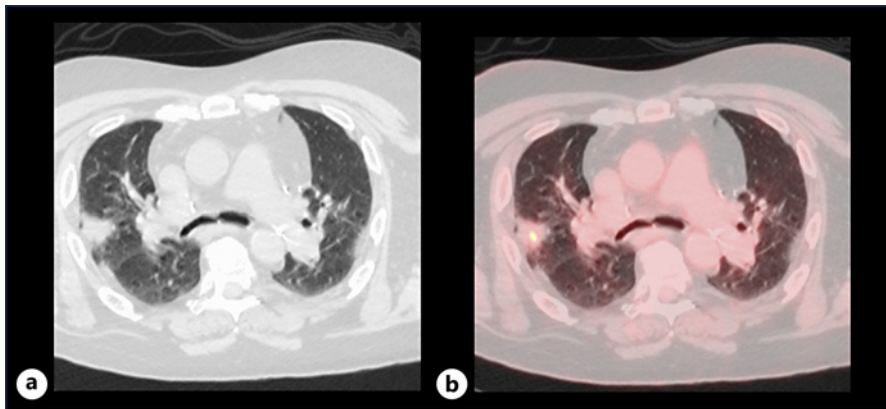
a Chest CT scan in October 2023. b Corresponding ^{18}F -FDG PET image. CT, computed tomography. PET, positron emission tomography. Irregular delineated consolidations (with surrounding ground glass opacities) bilaterally, with minimal FDG uptake.
